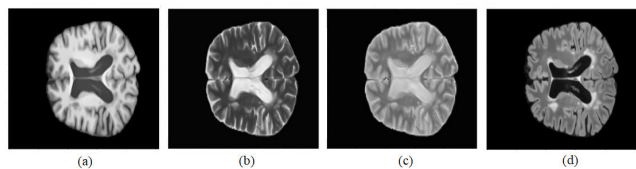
Different types of MRI. (a) T1-w MRI, (b) T2-w MRI, (c) PD MRI and (d) FLAIR MRI of an MS patient.
